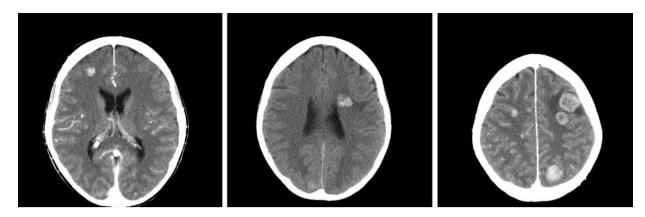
A cranial CT revealing multiple ring enhancing lesions in the frontal, parietal and occipital regions. Their size ranged from a few millimeters up to 2 cm. Isolated metastases were surrounded by edema.
